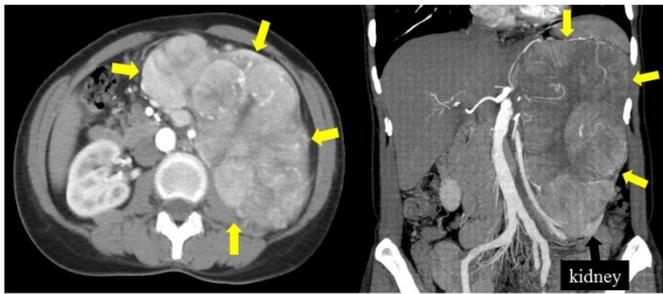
Contrast enhanced CT. CT scans showed the homogeneous enhancement tumor of left kidney, of which maximum diameter was 20cm, with no metastatic disease.
